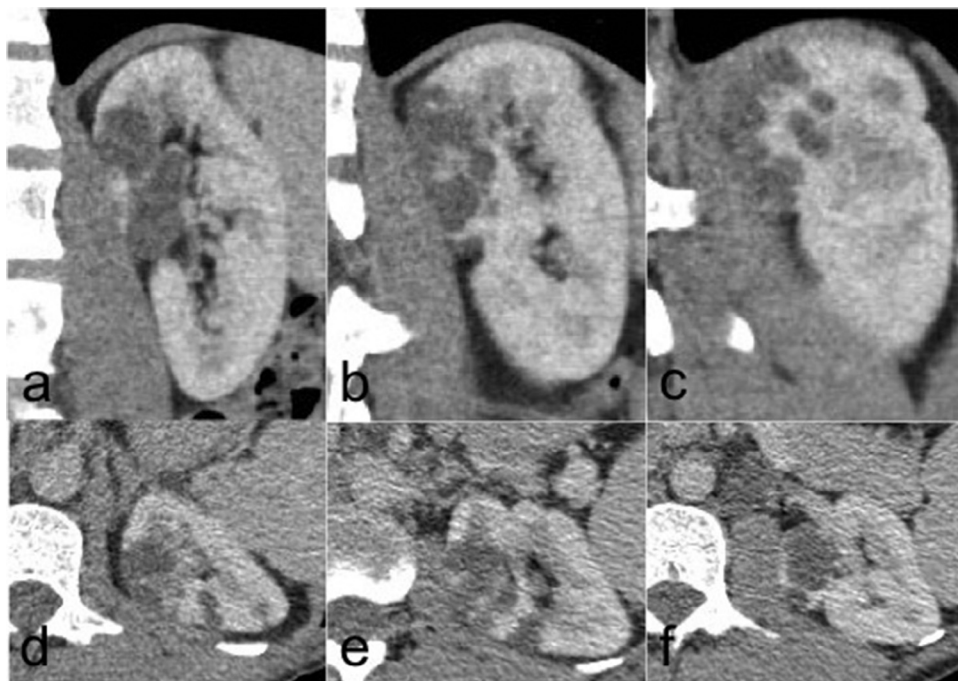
Sagittal (A-C) anterior to posterior and axial (D-F) upper pole to interpolar regions of the left kidney in the nephrographic phase of a triple-phase renal protocol computed tomography. Pre- and corticomedullary phases are not shown. This shows a focal intrarenal multiloculated cystic lesion in the anteromedial upper pole cortex.
